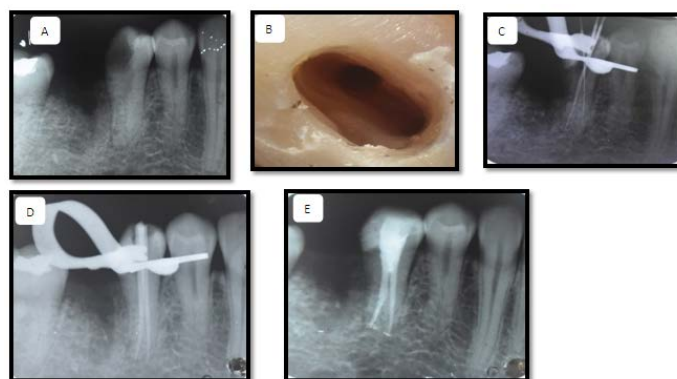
A) Preoperative radiograph of two-rooted 2nd premolar molar; B) Access cavity reveals one buccal and one lingual canal; C) Working length radiograph; D) The master apical cones confirmed the measured lengths; E) Post obturation Intraoral periapical radiograph.
